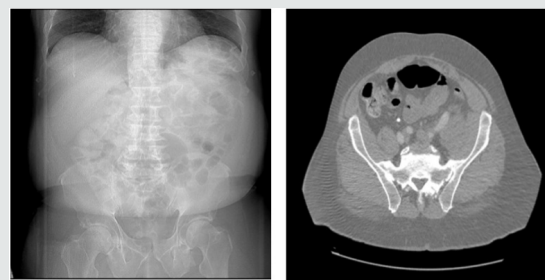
CT Abdomen/Pelvic with IV contrast.
